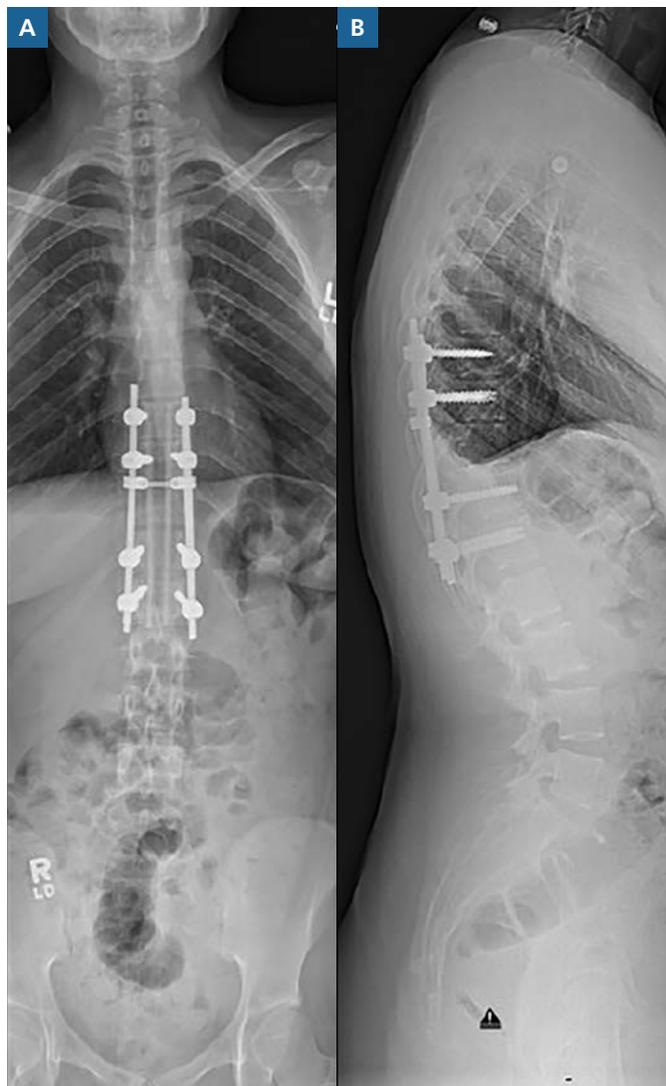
Postoperative A, anterior-posterior and B, lateral scoliosis radiographs. Status-post T10-T12 decompression, resection of T11 tumor, and posterior spinal instrumentation from T9 to L1. This instrumentation consists of bilateral pedicle screws at T9, T10, T12, and L1 stabilized by vertical connecting rods and a horizontal crosslink.
